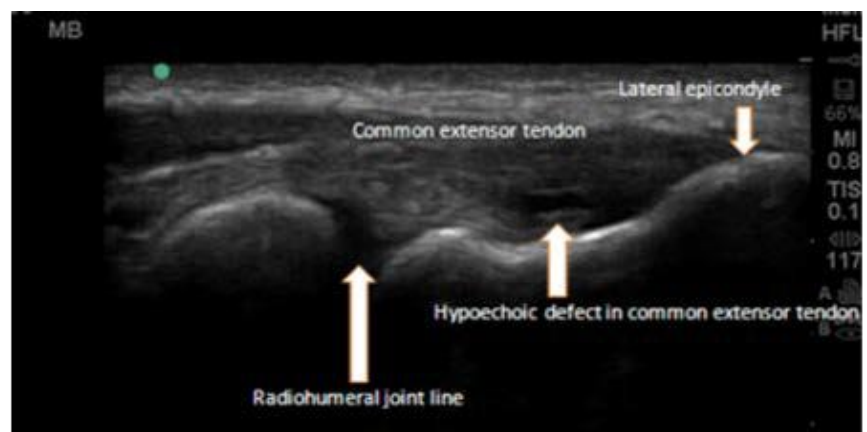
b. Abnormal Ultrasound of the Elbow
